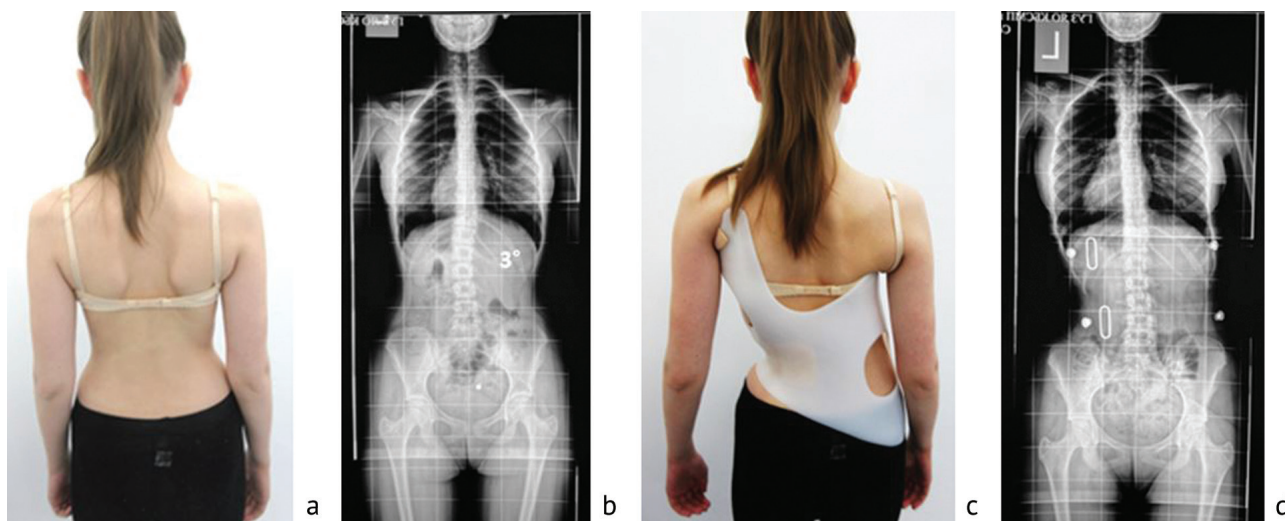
Appearance (a) and radiographs of the spine of patient C. (b) without the corset (August 2019, Risser sign = 2). Correction of the thoracolumbar curve maintained (Th10–L4) at 3°. Appearance (c) and AP view (d) of the spine of patient S. wearing corset No. 3 (December 2020). Correction of both curves maintained
